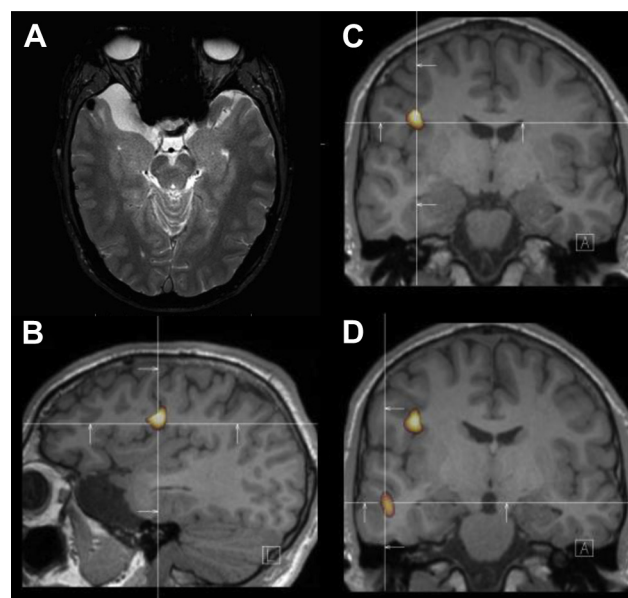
Cerebral MR and ictal SPECT images of patient 1. (A) Gradient echo T2* axial MR image showing a small round (hypointense) tumor in the right temporal pole and a neighboring arachnoid cyst. (B–D) Ictal/interictal technetium-99m HMPAO (^{99m}Tc -HMPAO) SPECT subtraction using BRASS analysis program. The software allows automatic fitting of brain perfusion scans and subtraction; (B) sagittal image, (C–D) coronal images, showing an increased blood flow maximal at the junction of the right dorsal mid-insula and the central operculum. (D) A cluster of increased blood flow was observed in addition within the right temporal pole, close to the tumor.
